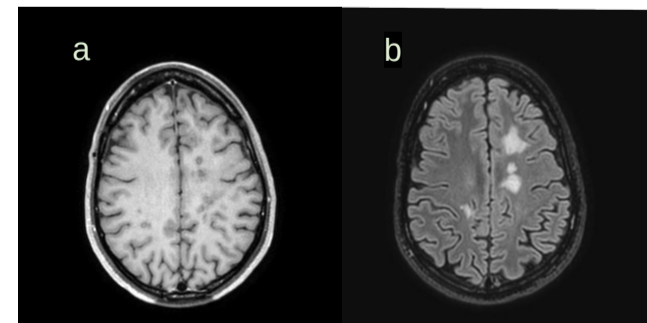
last MRI (Mar, 2025): T1 with gadolinium (a) and Axial FLAIR (b)
